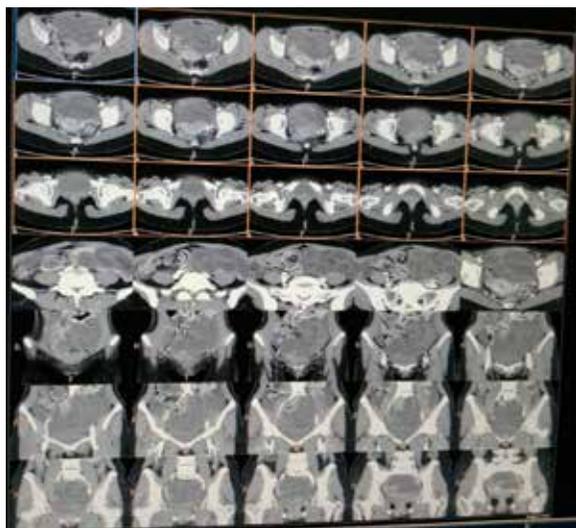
The CT scan of the Abdomen and Pelvis with contrast shows dilated bowel loops with no contrast seen in the bowel lumen suggestive of Acute Intestinal Obstruction.
